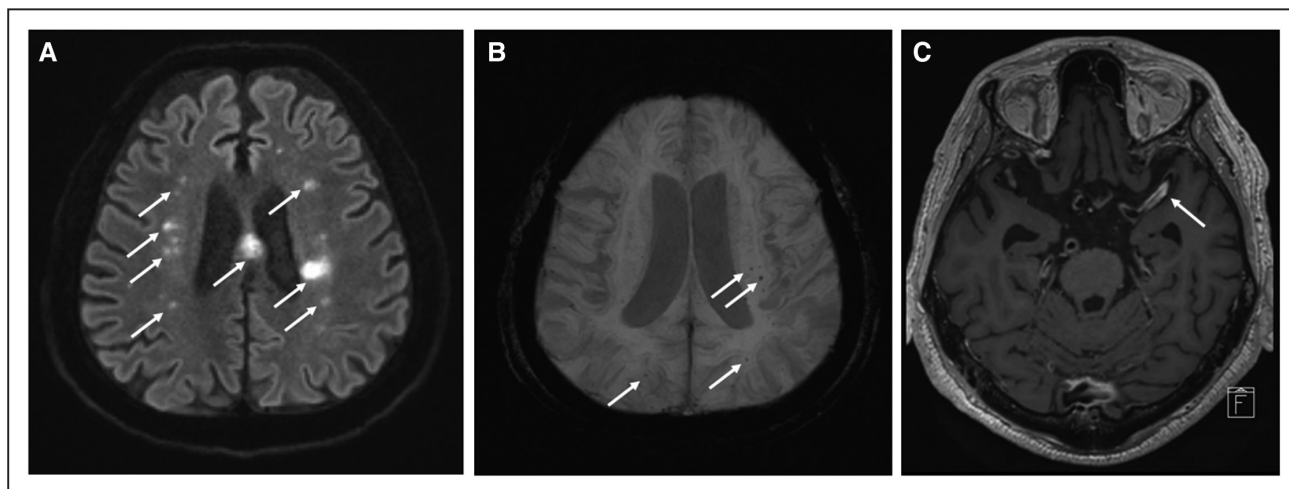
Magnetic resonance imaging (MRI) findings in patient 6.
